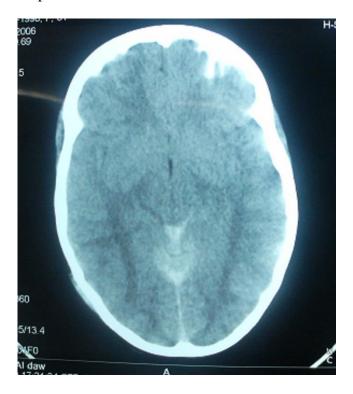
CT of another patient with obliteration of Sulci, Ventricular system and basal cisterns around brain stem.
